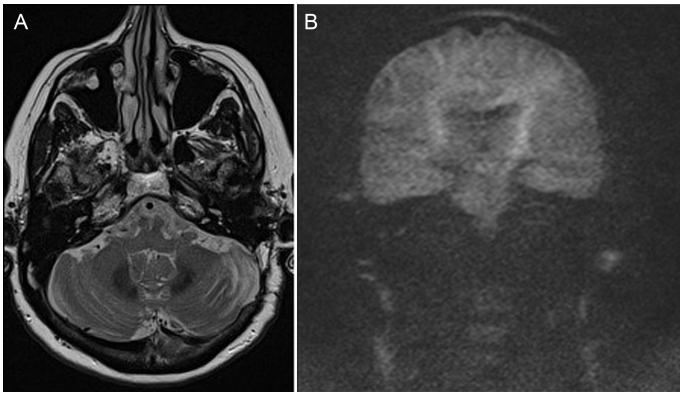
Postoperative radiological follow-up in patient 2. In panel (A), the axial MRI contrast-enhanced T1-weighted images and in panel (B), the coronal DWI scans were negative for residual lesion.
